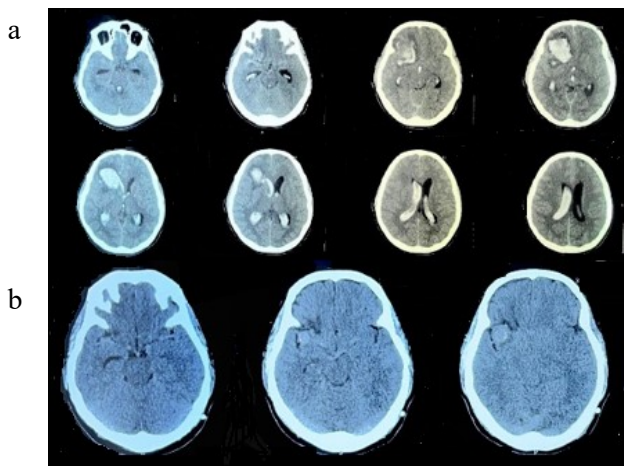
Head CT scan without contrast: (a) before VP shunt, (b) six months after VP shunt
